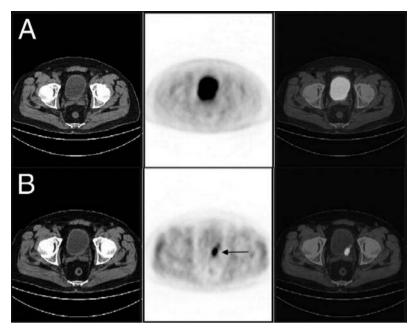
(A) FDG in the bladder. (B) Additional delayed high resolution images of the pelvic region (following the acquisition of routine images) after furosemide injection, hydration and voiding show a hypermetabolic lesion in the posterior wall of the bladder and wall thickening consistent with malignancy. Biopsy diagnosed bladder cancer.
